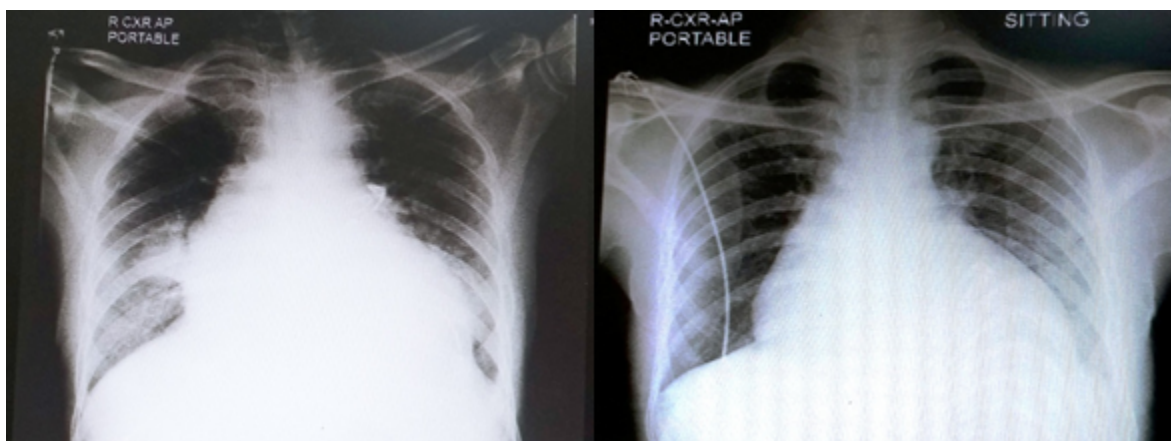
Showing right paracardiac patchy consolidation with cardiomegaly on admission in first chest X-ray; second chest X-ray showing significant improvement in lung shadows with sharp costophrenic angles on repeat chest X-ray after 4 days.
